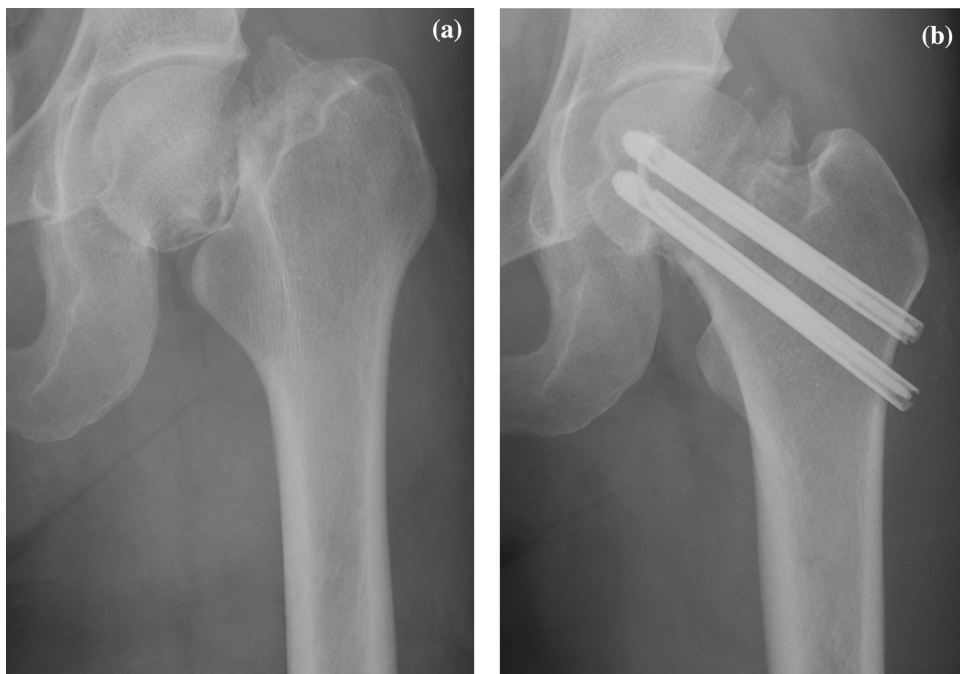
Initial post-traumatic (a) and immediate postoperative (b) anteroposterior radiograph of the left hip.
